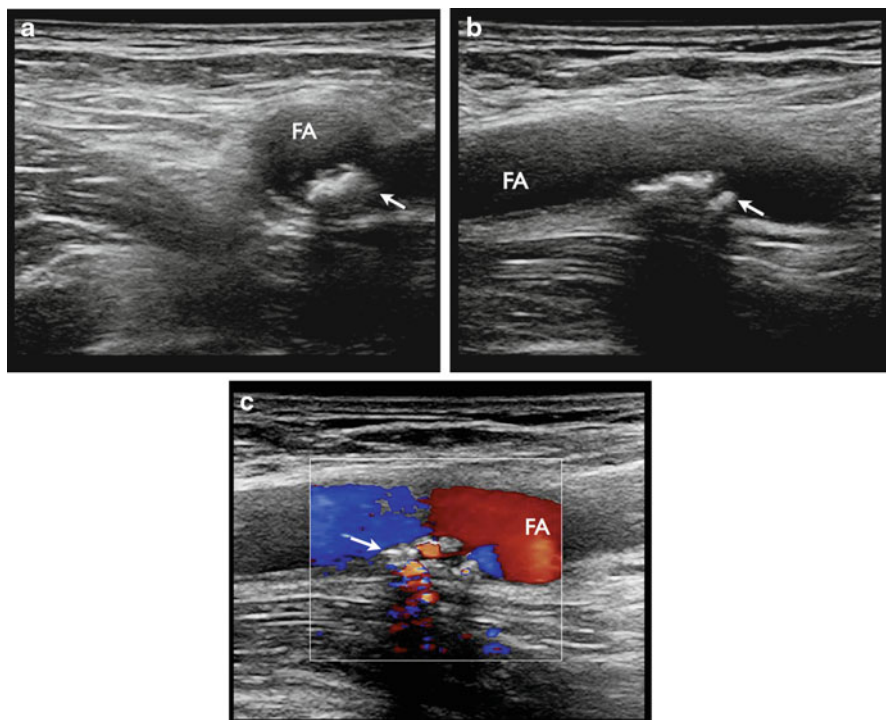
(a) Short-axis view of the femoral artery with thrombus seen within lumen. (b) Long-axis view of the same artery. Notice the posterior acoustic shadowing that appears deep to the lesion. (c) Long-axis view with color Doppler demonstrates partial occlusion to blood flow. *FA* femoral artery, *arrow* thrombus
